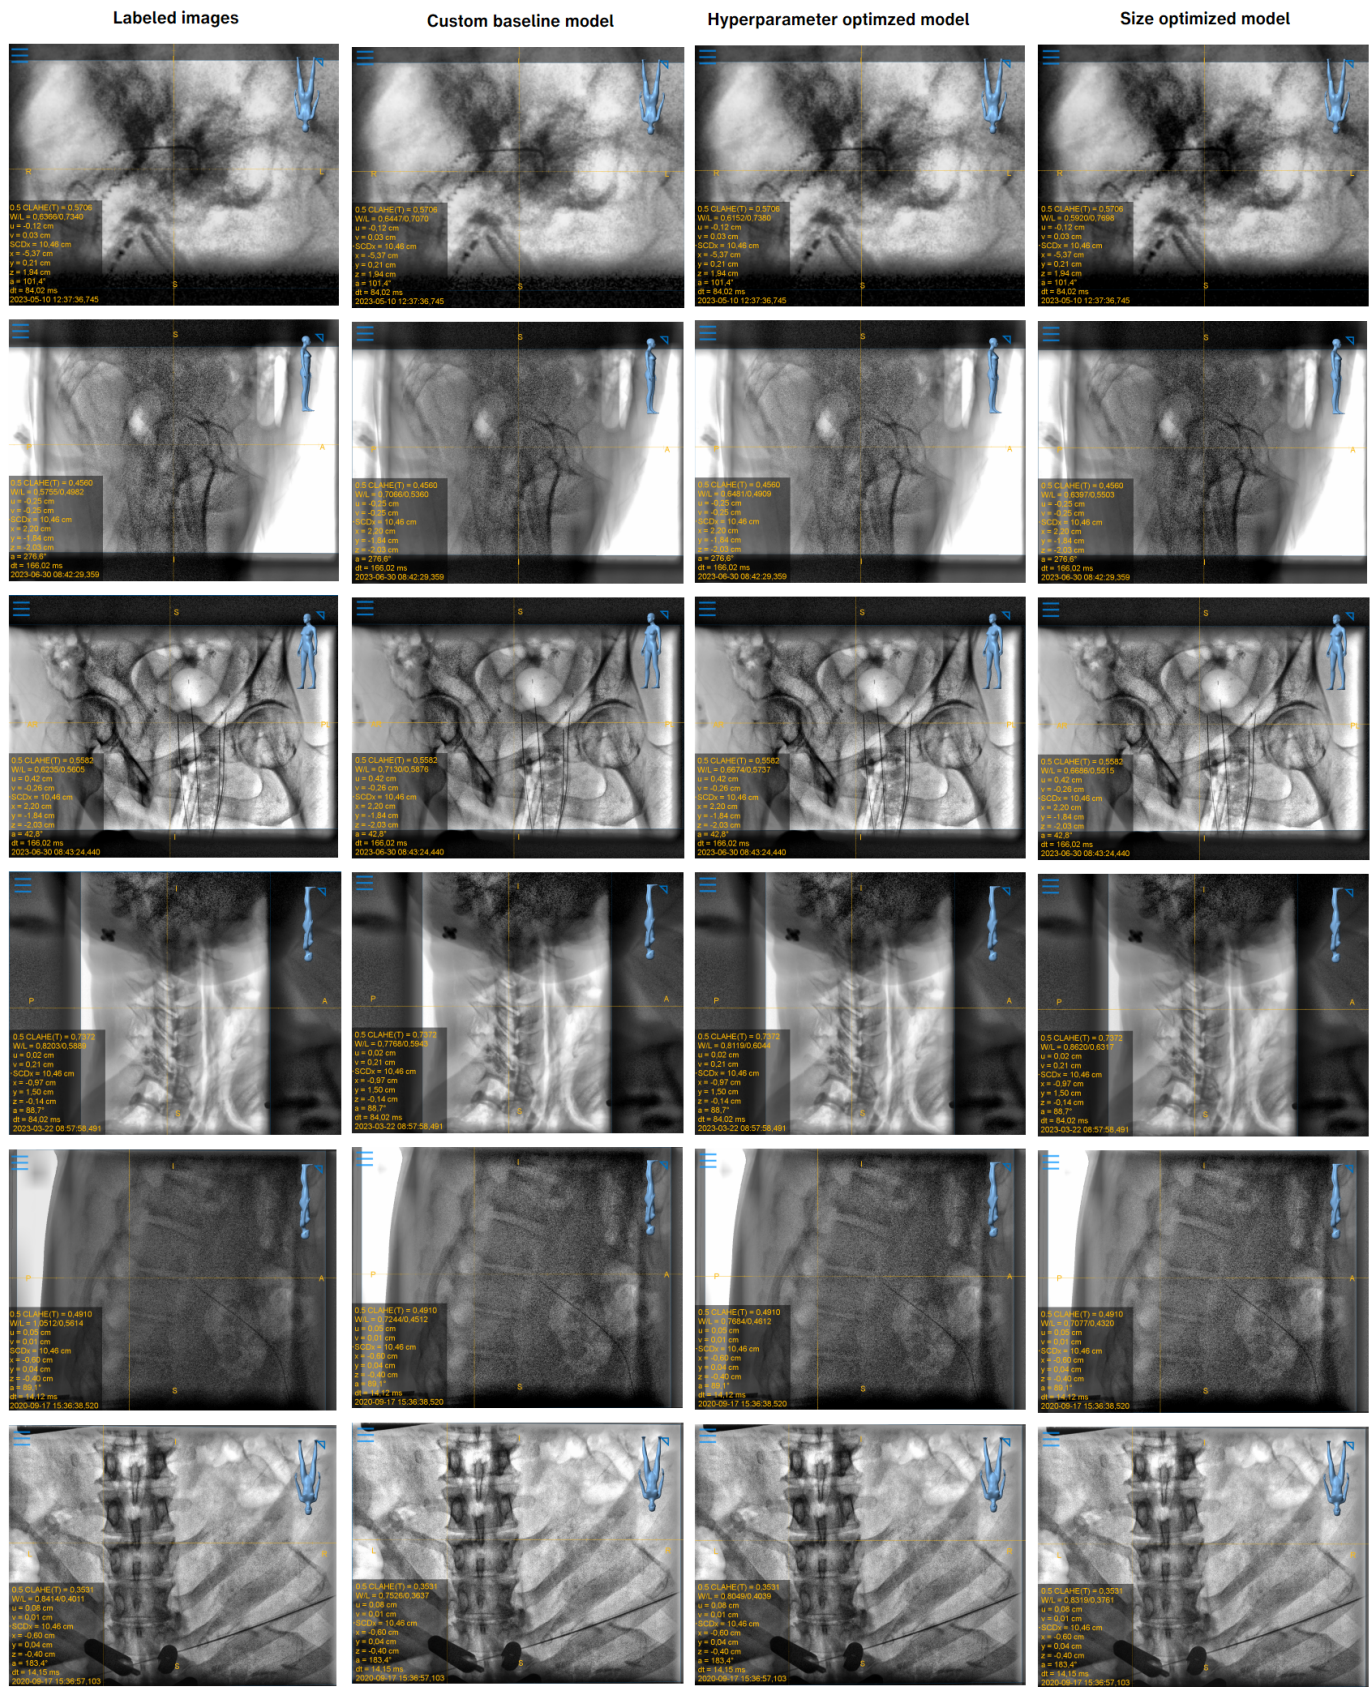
(continued): Example x-rays visualized with the label and the predicted window-leveling parameters. *Left column:* X-rays visualized with label values. *Left middle row:* X-rays visualized with parameters predicted by baseline model. *Right middle column:* X-rays visualized with parameters predicted by the model with optimized hyperparameters. *Right column:* X-rays visualized with parameters predicted by the model with optimized size.
